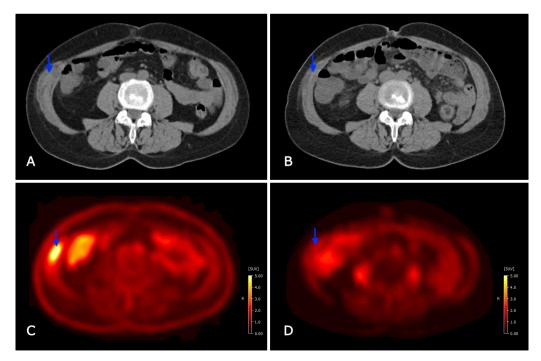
(A) Initial CT scan of abdominal wall showing invasion of mesothelioma into skeletal muscle and fibroadipose tissue. (B) CT scan of abdominal wall 6 months after completing chemotherapy showing resolution of mesothelioma. (C) Initial positron emission tomography (PET) scan of abdominal wall showing invasion of mesothelioma into skeletal muscle and fibroadipose tissue. (D) PET scan of abdominal wall 6 months after completing chemotherapy showing resolution of mesothelions.
